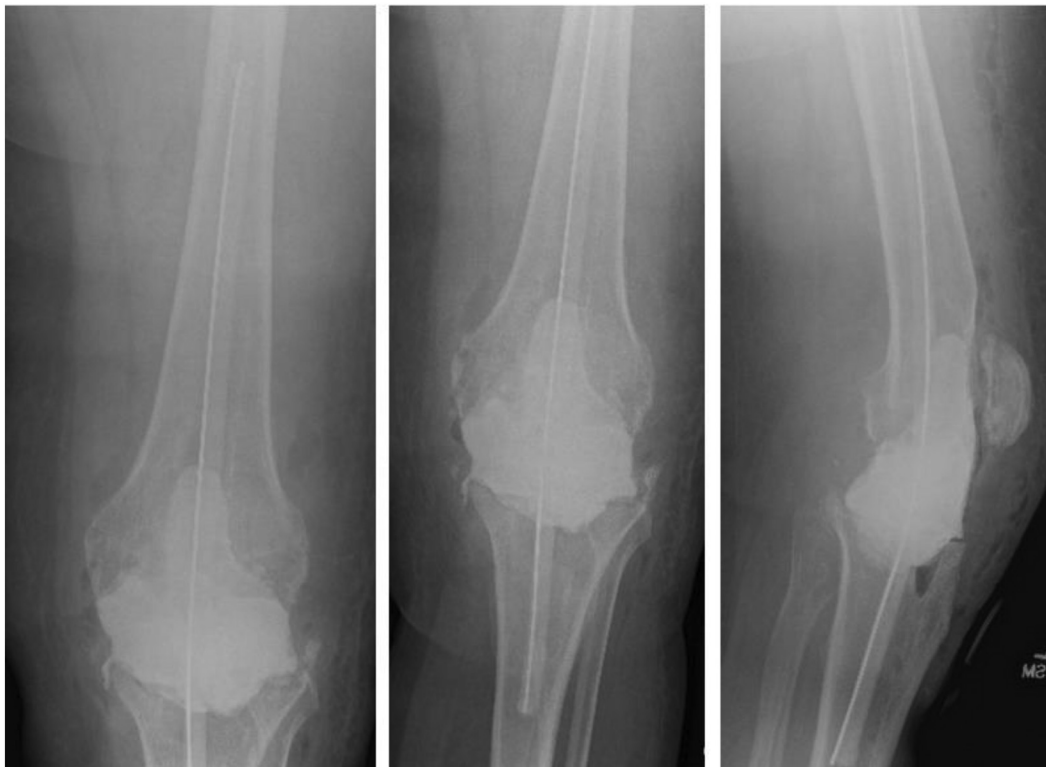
Anteroposterior (left, middle) and lateral (right) radiographs of the left knee with a static antibiotic-laden cement spacer.
